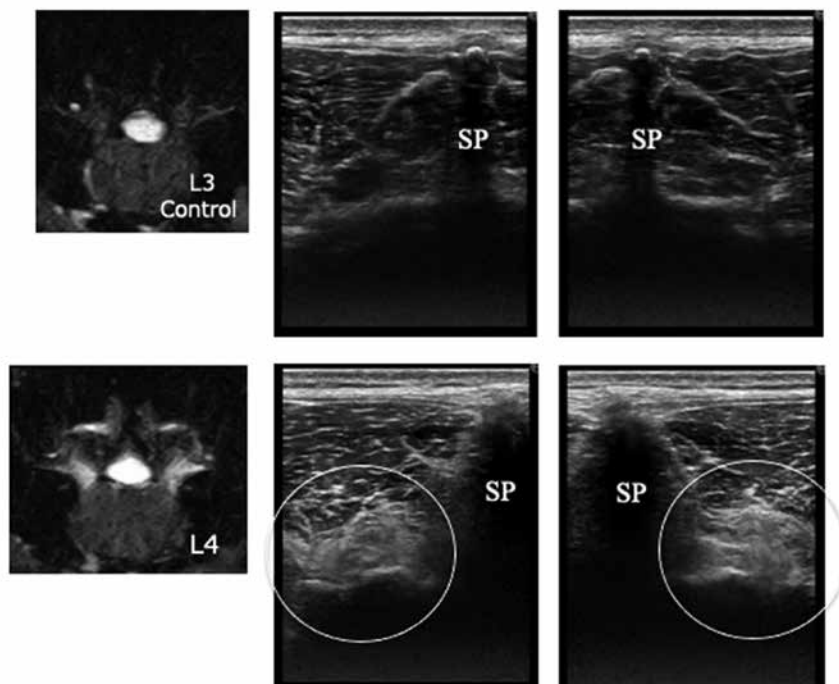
Test case of ultrasonography used in an 18-year-old boy with L4 stress fracture of the lamina presenting with ESCs on MRI, with disarray of the muscular fibers.
